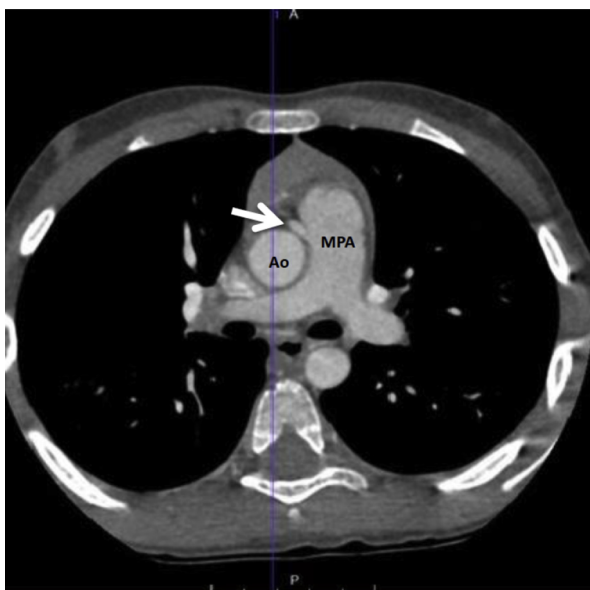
Cardiac computed tomography shows a retrograde blush of contrast from the origin of the RCA (*white arrow*) into the main pulmonary artery (MPA). Ao, Aorta.
